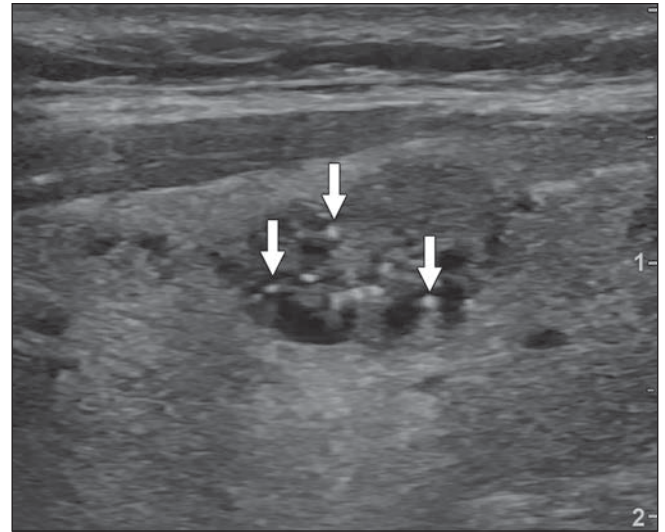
Transverse ultrasound image in 46-year-old woman shows isoechoic, mixed cystic-solid nodule with category of TR2 (2 points). Comet tail artifacts (arrows) could be misinterpreted as punctate echogenic foci. This would result in categorization of nodule as TR4 (5 points) and biopsy with 1.5-cm threshold instead of no biopsy at any size.
